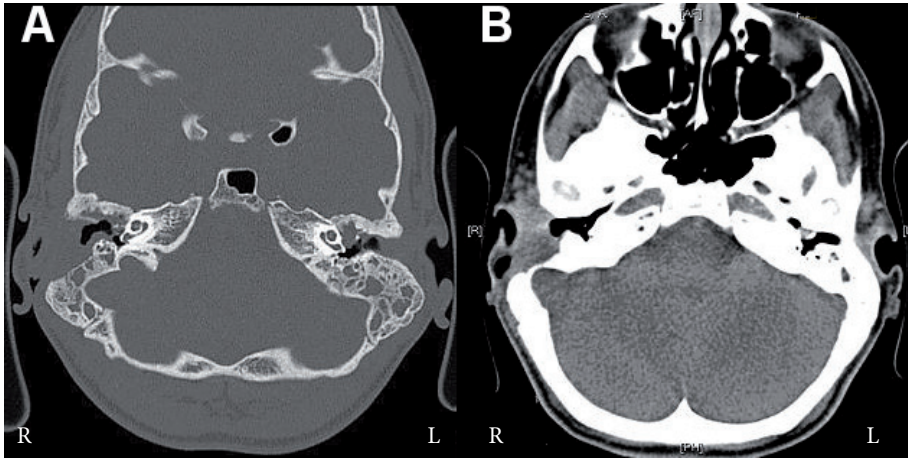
(A+B): Computed tomography images of a patient with *Mycobacterium abscessus* otomastoiditis. There is extensive bone destruction in the right mastoid and associated right-sided mucosal swelling.
